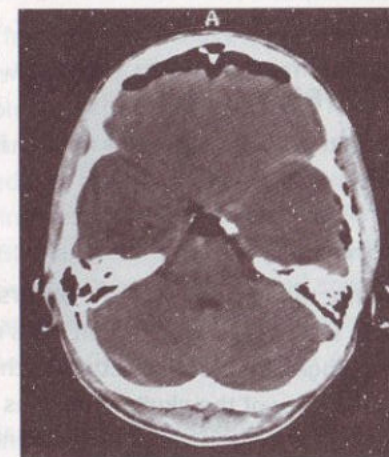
CT scan showing pneumocephalus in bifrontal location
